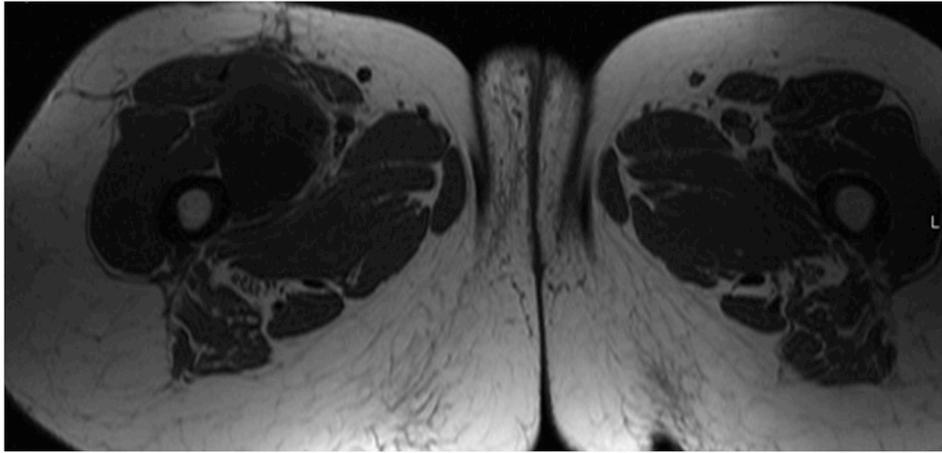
Imaging findings of a well differentiated (G1) fibromyxoid sarcoma with a low Ki67-index (5%) in a 61 years old patient. a. T1-weighted axial image shows a homogenous lesion within the right musculus quadriceps femoris. The lesion is hypointense compared to adjacent muscle tissue lesion.
